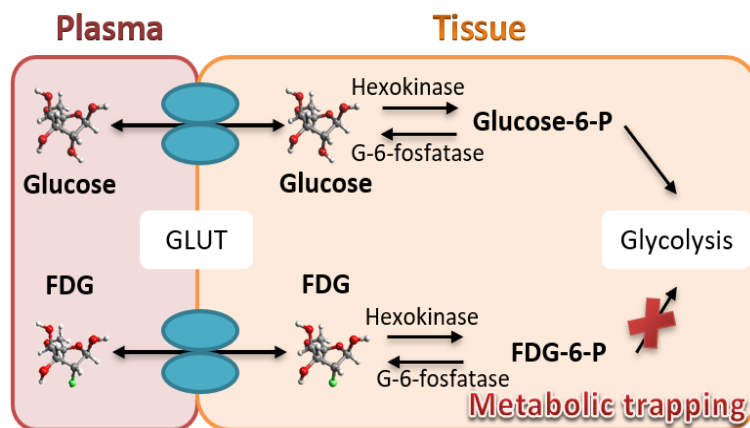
Metabolic trapping. Mechanism of FDG uptake inside the cell.
